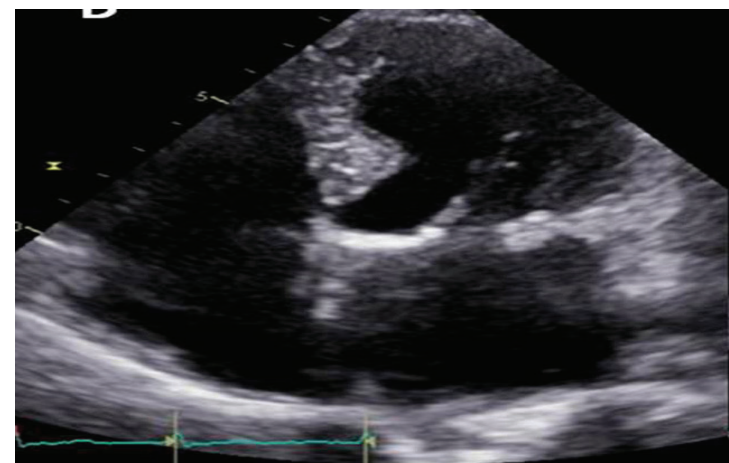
Transthoracic echocardiography (TTE) shows complete thrombus resolution in left atrium.
